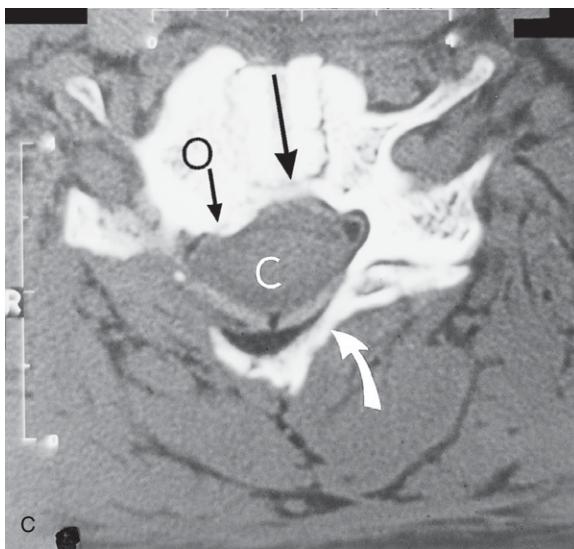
Cont'd (C) Cervical spine CT axial image showing the laminectomy that was performed on the right side in an attempt to remove pressure from the disc/osteophyte complex projecting against the pain-sensitive dural tube anteriorly. O = osteophyte; the large arrow indicates the original surgical approach which is directed to the patient's left side. The left lamina is shown by the curved white arrow and the corresponding lamina on the right side has been surgically removed. C = spinal cord within the spinal canal.
